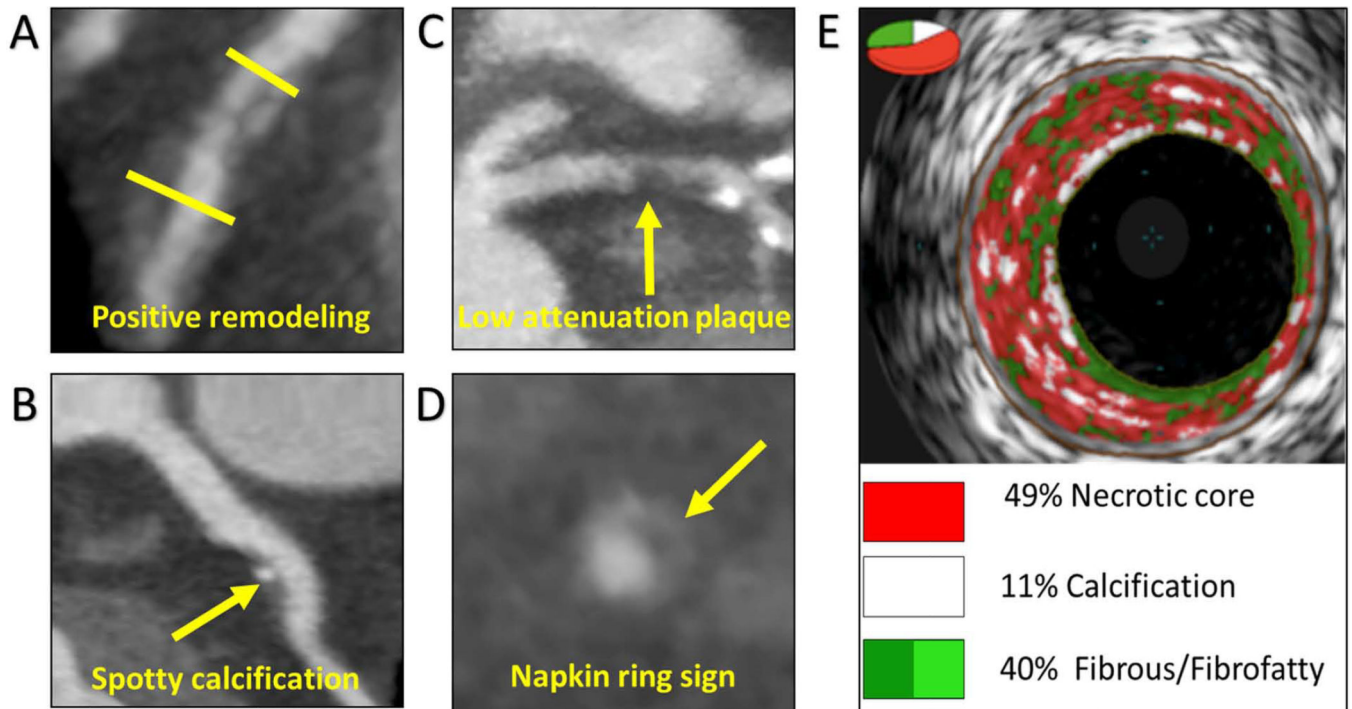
Coronary Plaque Features on Coronary Computed Tomography Angiography and Intravascular Ultrasound.
